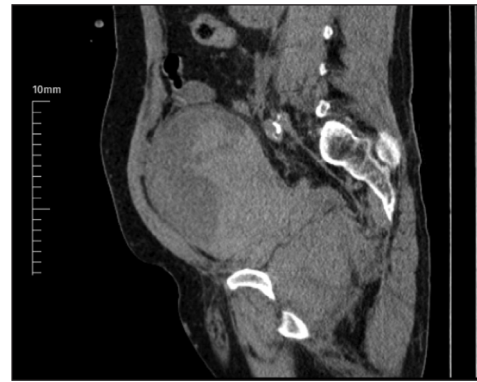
Hematoma filling the pelvic region anterior to the bladder on non-contrast abdominal computed tomography.
